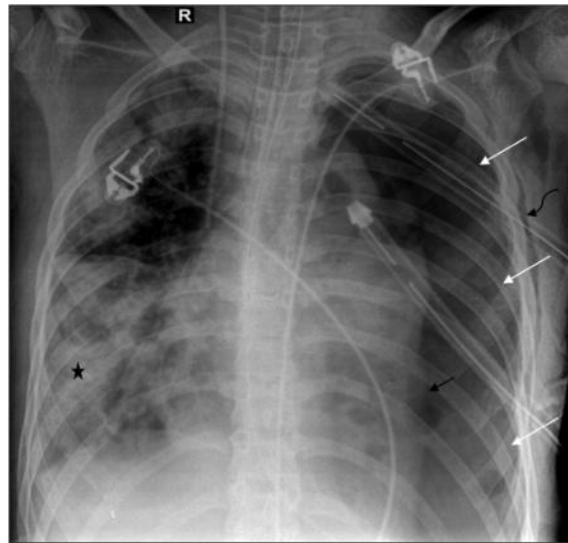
Showing a CXR radiograph of patient under treatment for ARDS with focal patchy consolidation in right mid and lower zone
